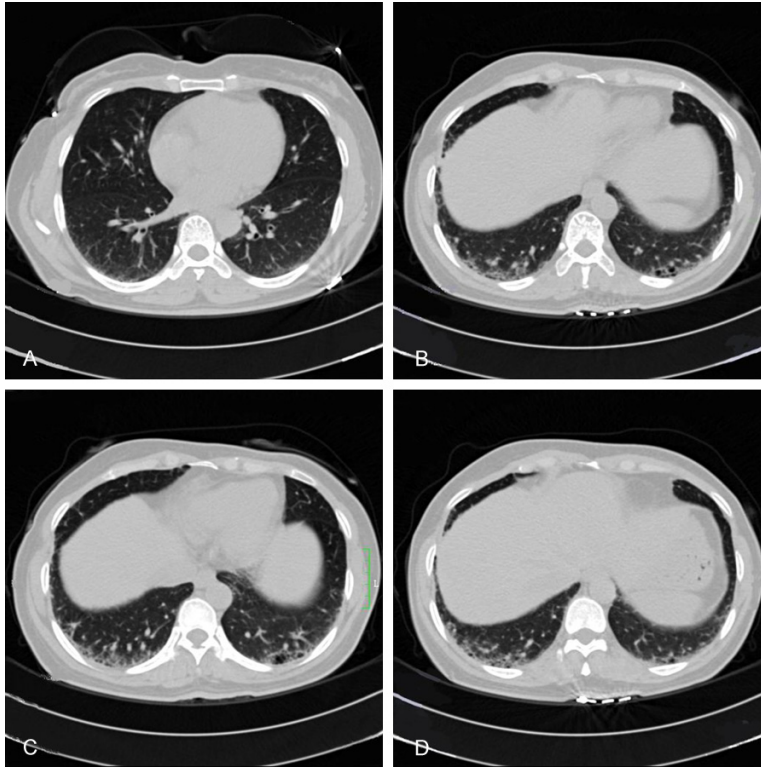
A-D. HRCT scans revealed patchy, reticular opacities and diffuse honeycombing involving mainly the subpleural and basal segments of the lower lobes.
